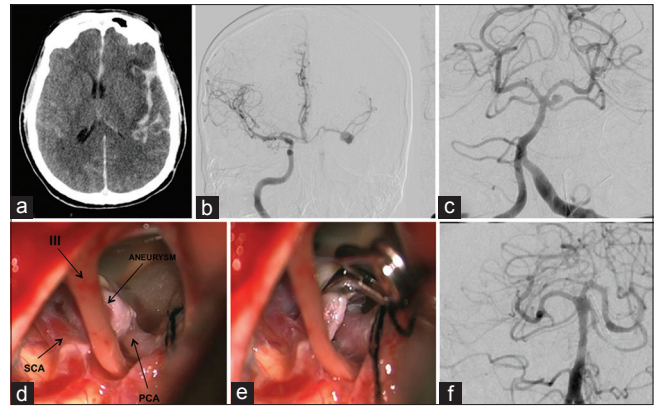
(a) CT showed SAH with a hematoma in the left temporal lobe in a 45-year-old male seen in the emergency with sudden onset headache and loss of consciousness. (b) DSA showing a left MCA and ICA aneurysm, and (c) shows a superiorly directed SCA aneurysm. (d) Operative pictures seen through a subtemporal approach with the aneurysm arising from the SCA, the oculomotor nerve and PCA are seen in close relation. (e) The final clip placement across the aneurysm, and (f) DSA showing complete occlusion of the aneurysm
